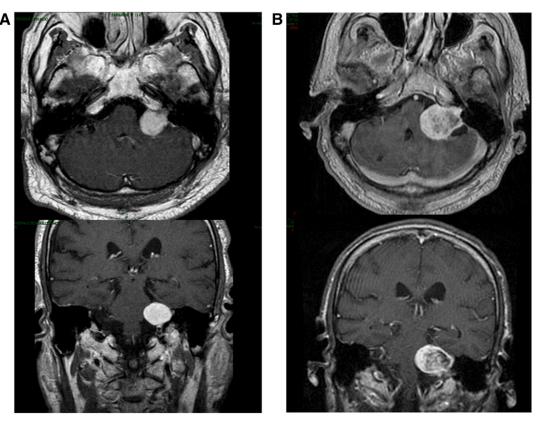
A, Axial and coronal MR images (T1 weighted with contrast) obtained from a 52-year-old woman with left vestibular schwannoma who received radiotherapy for a 2.3 cm diameter tumor. B, Enlargement of the vestibular schwannoma with loss of central enhancement and cystic formation 1 year after radiotherapy.
